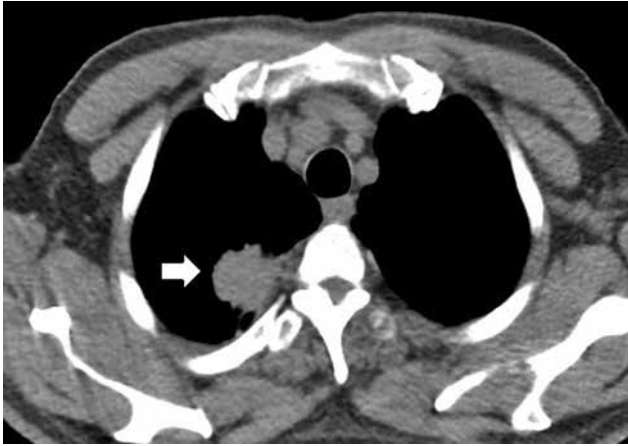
A contrast computed tomography image showing the lesion in the right upper lobe of the thorax (arrow).
